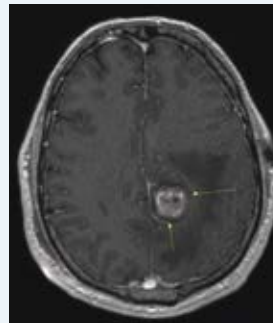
MRI taken 24 hours after ablation showing the extent of ablation (thin eggshell of enhancement indicated by arrows) and loss of contrast enhancement (hyperintensities are postablation blood and protein products).
